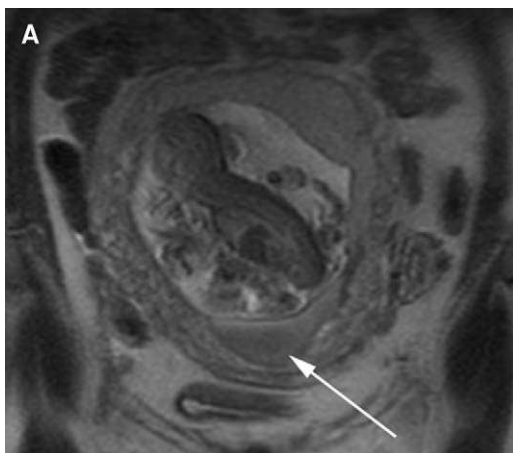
Pitfall of fluid motion: dark fluid caused by blood products. (A) Sagittal T2-weighted image shows dark fluid above the internal os (arrow). (B) Sagittal T1-weighted image (TR/TE 88.2/1.5) shows this same area to have heterogenous slightly increased signal, consistent with marginal subchorionic hematoma (arrow). Also note the adnexal cyst (C).
